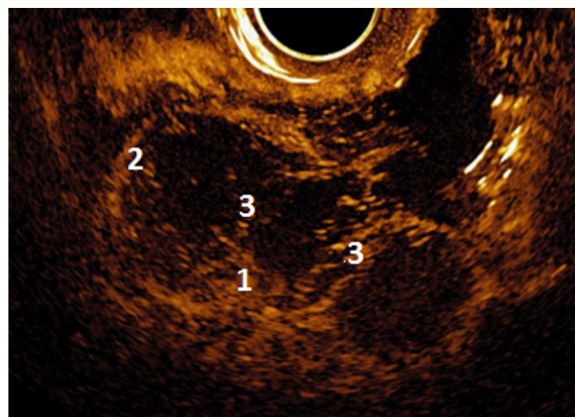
Ultrasonic tomogram of the tumor of the left ovary patient T diagnosed with moderately differentiated endometrioid endometrial adenocarcinoma endometrium (the regime of contrast-enhanced ultrasound - late phase): 1- papillae structures; 2- capsule; 3- partitions.
